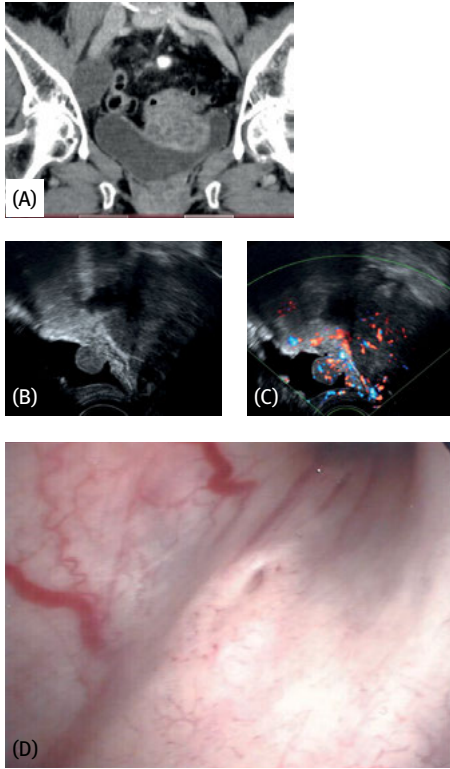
(A) Coronal CT reveals a pelvic recurrence four months after radical hysterectomy with bilateral ovariectomy, pelvic and para-aortic lymphadenectomy and omentectomy in stage pT1b, N0, R0. The tumor has noticeably breached the bladder wall, predominantly on the left side; (B) said breach of the bladder wall is also nicely depicted in gray-scale sonography; (C) color Doppler sonography confirms both strong perfusion in the tumor and that the bladder wall has ruptured. The strongly anechoic area at 12 o'clock, also visible as such in gray-scale sonography, is entirely without vasculature and corresponds to an area of necrosis; (D) the superficial atypical vessels visualized in Doppler sonography were also clearly visible in cystoscopy, to the right of the left ureteral orifice.
